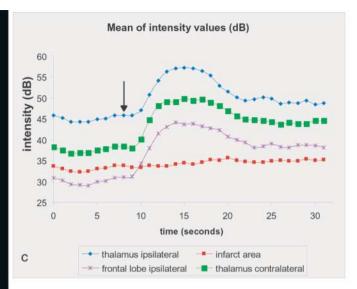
Transcranial B-mode sonography in the axial diencephalic plane in a 49-year-old female patient with malignant MCA infarction following decompressive craniectomy before a and after b application of the contrast agent. The region of the perfusion deficit is hypoechoic on both images and is marked by the red circle. After application of the contrast agent, the area of hypoperfusion is clearly delineated. The ipsilateral thalamus and adjacent area of the infarct area near the midline (further from the penumbra) show hyperperfusion. c shows the time intensity curves showing the mean intensity values in the area of infarction, in the thalamus ipsi- and contralaterally and in the frontal lobe ipsilaterally. No increase of intensity in the area of infarction (red line) has occurred whereas in the ipsilateral thalamus and midline area (blue line) hyperperfusion with a clear increase in intensity can be observed. After the bolus effect of approx. 9 seconds a steadystate plateau with higher intensities than the baseline intensities can be observed. Arrow: injection of the contrast agent.
